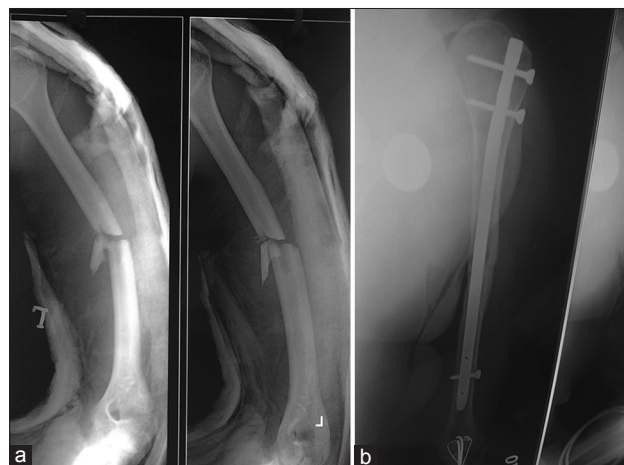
(a) Preoperative radiograph of fracture shaft of humerus of 46-year-old man; (b) Postoperative radiograph showing fracture fixation with interlocking nail.
